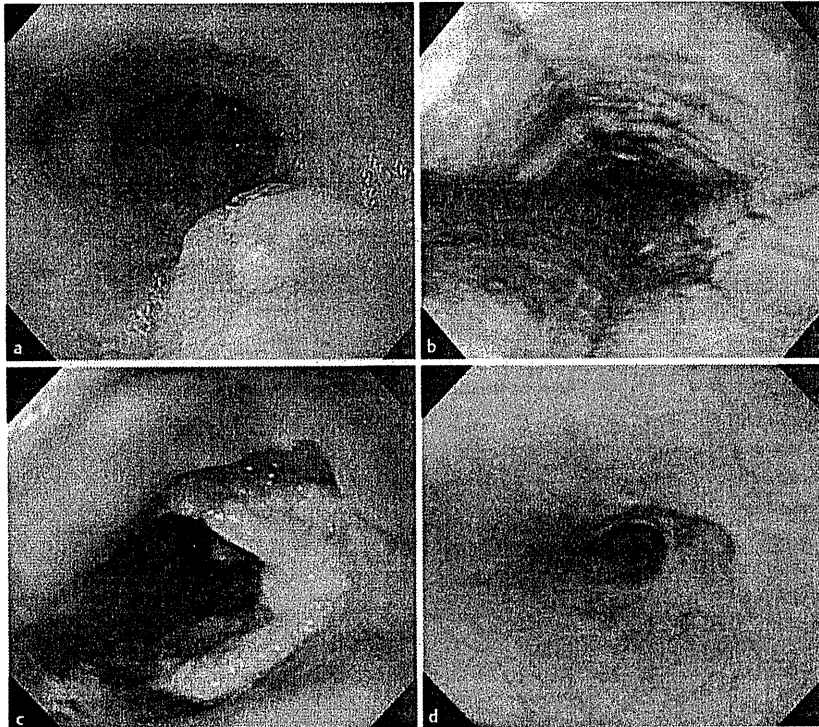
A patient in whom complete response was achieved with salvage photodynamic therapy (PDT). a Local recurrence was detected after chemoradiotherapy and evaluated as uT1 with endoscopic ultrasound. b At 3 days after salvage PDT, circumferential ischemic change was observed. c At 1 month after salvage PDT, deep ulceration with dense necrotic tissue was observed at the primary site. d At 3 years after salvage PDT, treatment was evaluated as a complete response without any recurrence.
